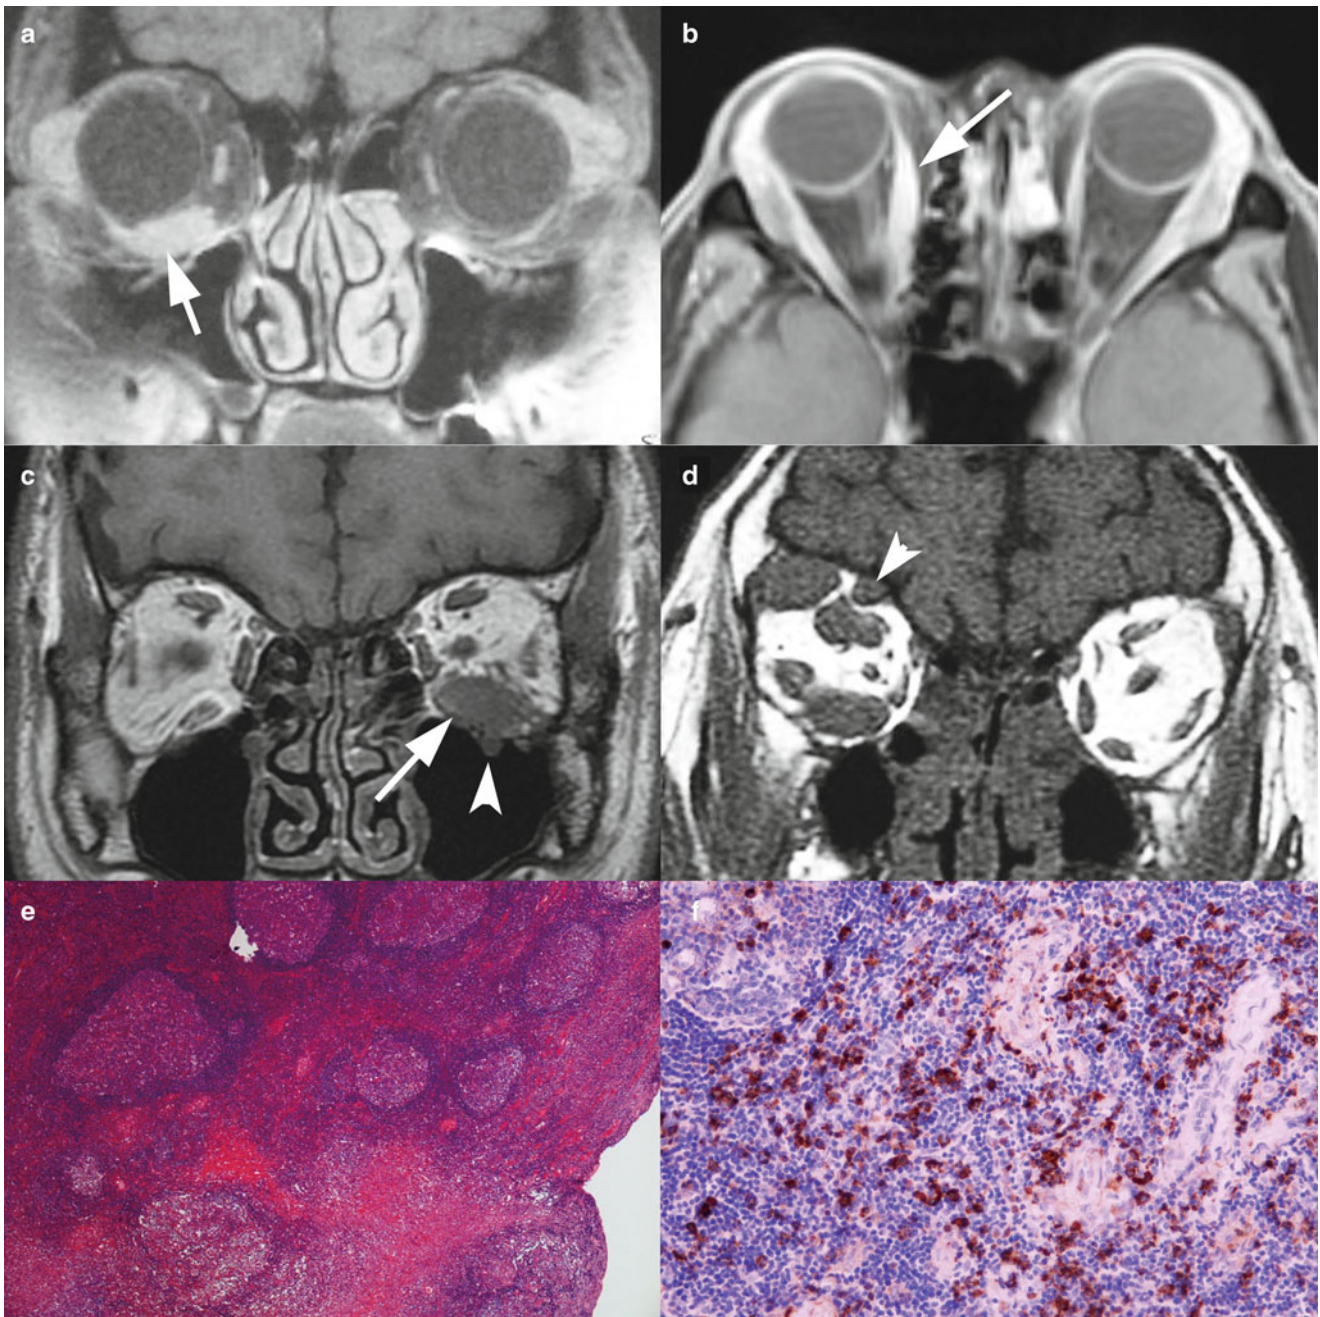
MRI and pathological findings of IgG4-related extraocular myositis. (a) A 46-year-old woman. Serum IgG4 value 209 mg/dL. In addition to bilateral lacrimal gland swelling, right inferior oblique muscle swelling (*arrow*) is seen. (b) A 45-year-old man. Serum IgG4 value 914 mg/dL. In addition to bilateral lacrimal gland swelling, right medial rectus muscle swelling (*arrow*) is seen. (c) A 65-year-old man. Serum IgG4 value 404 mg/dL. Left inferior rectus muscle swelling (*arrow*) and lesions around the infraorbital nerve (*arrowhead*) are seen. (d)
